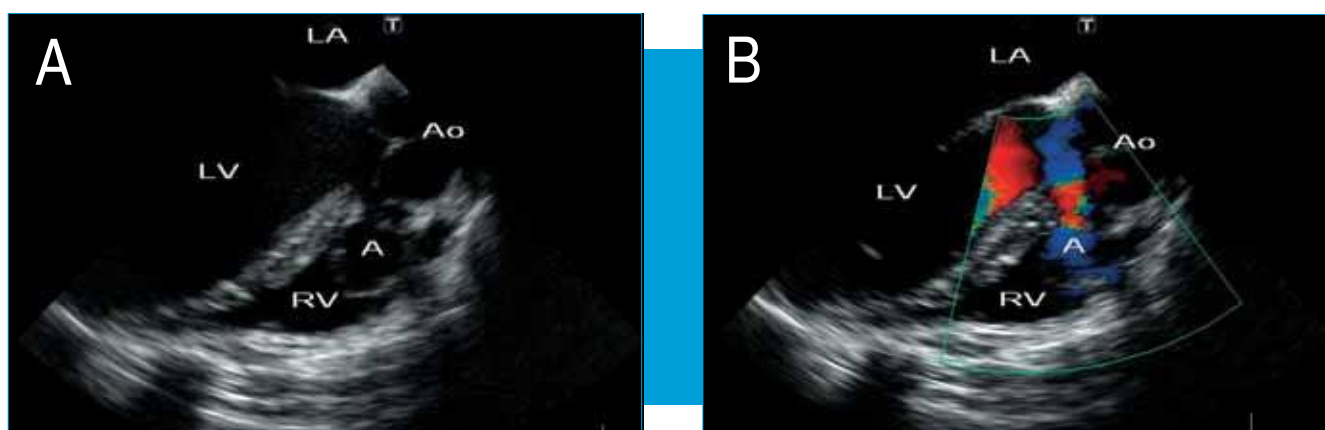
Transesophageal echocardiography demonstrated membranous ventricular septum aneurysm bulging toward the right ventricle (A). Doppler echocardiography revealed blood flow directly from the left ventricular cavity into the aneurysm through small ventricular septal defect (B).
